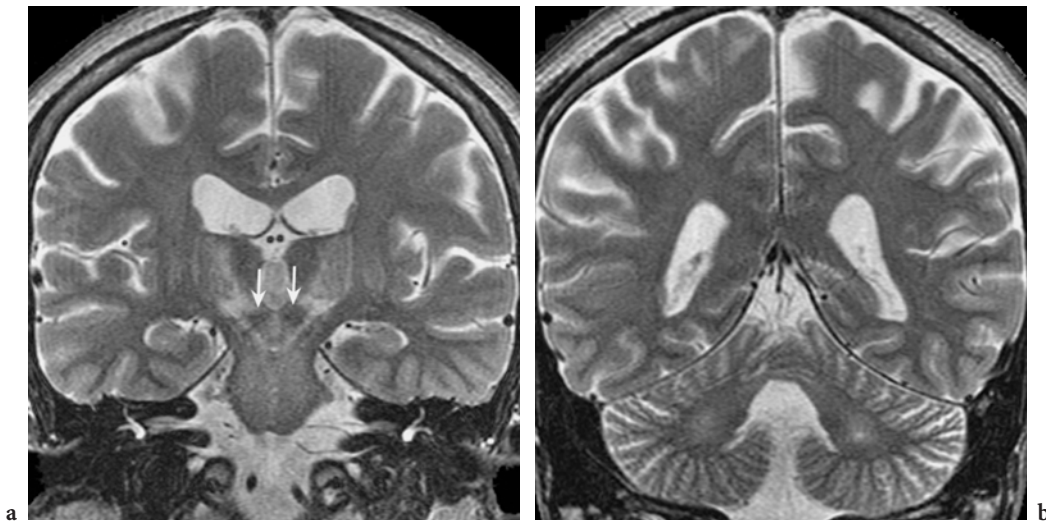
a, b. Cerebellar white matter lesions and diffuse brain atrophy in Wilson disease on coronal T2-weighted fast spin-echo images. a Enlargement of both extra- and intracerebral CSF spaces. Symmetrical, ill-defined hyperintensities within upper mesencephalic and diencephalic structures. Note the hypointense appearance of the red nuclei (arrows). b Ill-defined central cerebellar white matter lesions in conjunction with cerebellar atrophy
